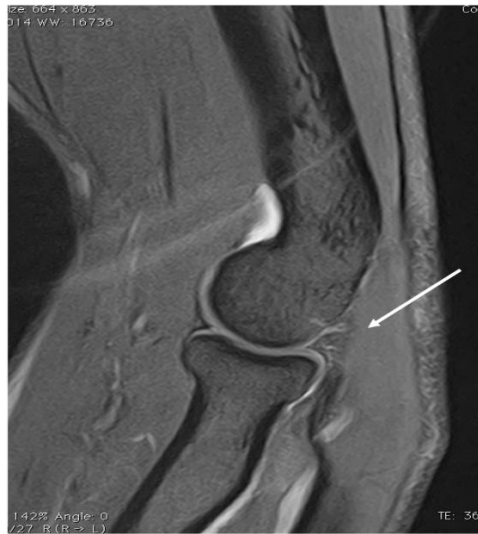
Sagittal magnetic resonance image showing an enlarged and thickened posterolateral synovial fold (white arrow).
